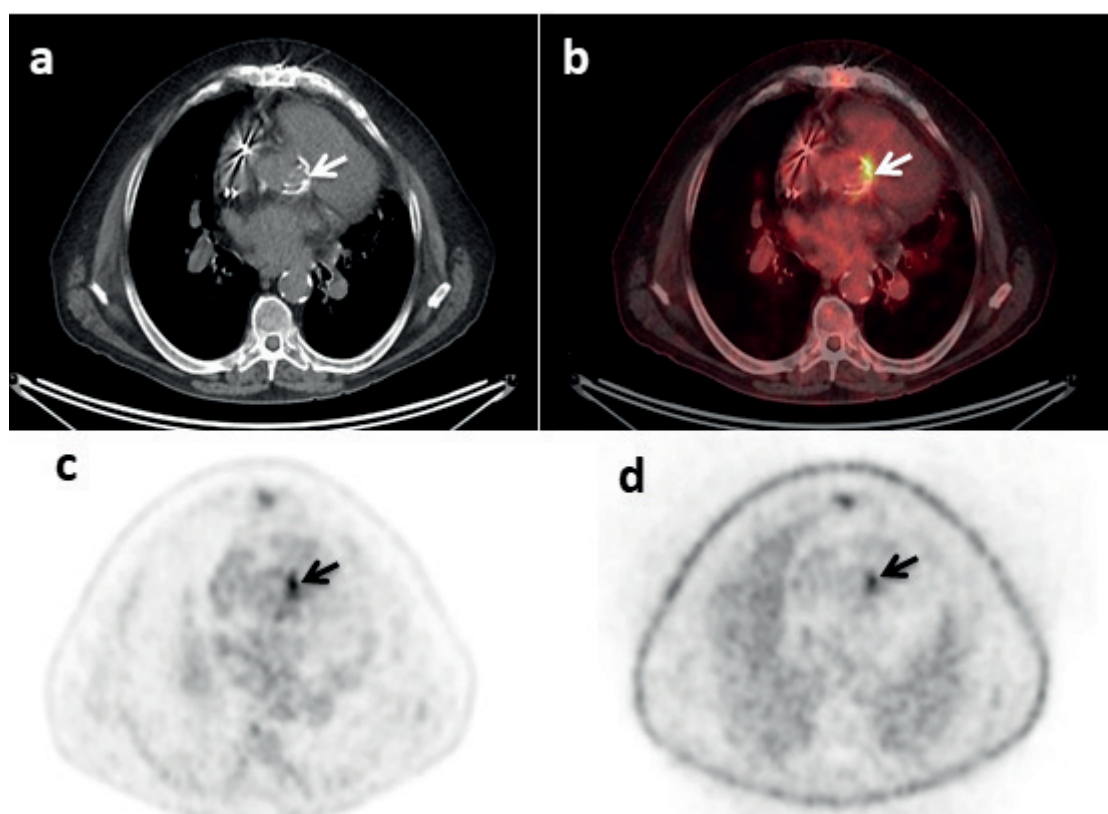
18F-FDG PET/CT in a 76-year-old man with a biological aortic prosthetic valve implanted 1 year before referred for suspected IE. The valve is evident (arrow) in the CT transaxial image (a) of PET/CT scan. PET/CT fusion transaxial image (b) shows a linear increased uptake in the left lateral region of the valve (arrow). This pathological uptake is evident in the PET images both with attenuation correction (c) and without (d) attenuation correction and it is easily differentiated from the surrounding tissue.
